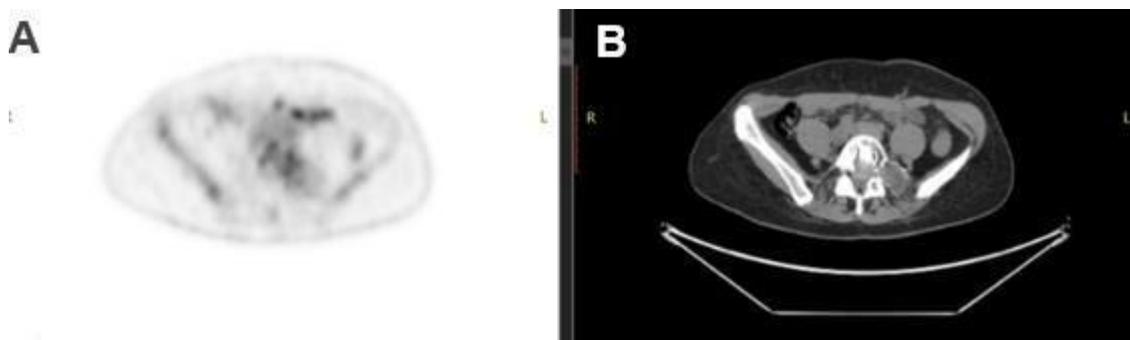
A. PET image in transverse plane, confirming abnormal FDG uptake within the metastatic lesion. B. CT image at the same level.
